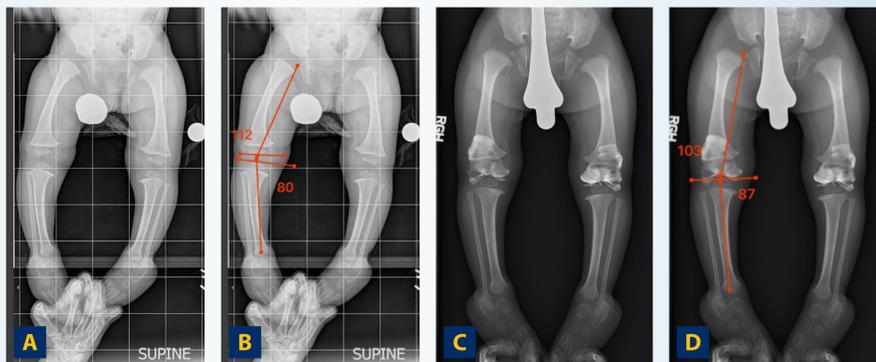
A and B, Apparent femoral and tibial varus on AP view full length standing radiograph in a patient with multiple epiphyseal dysplasia. C and D, Same patient after arthrogram with normal tibia and femoral varus.
